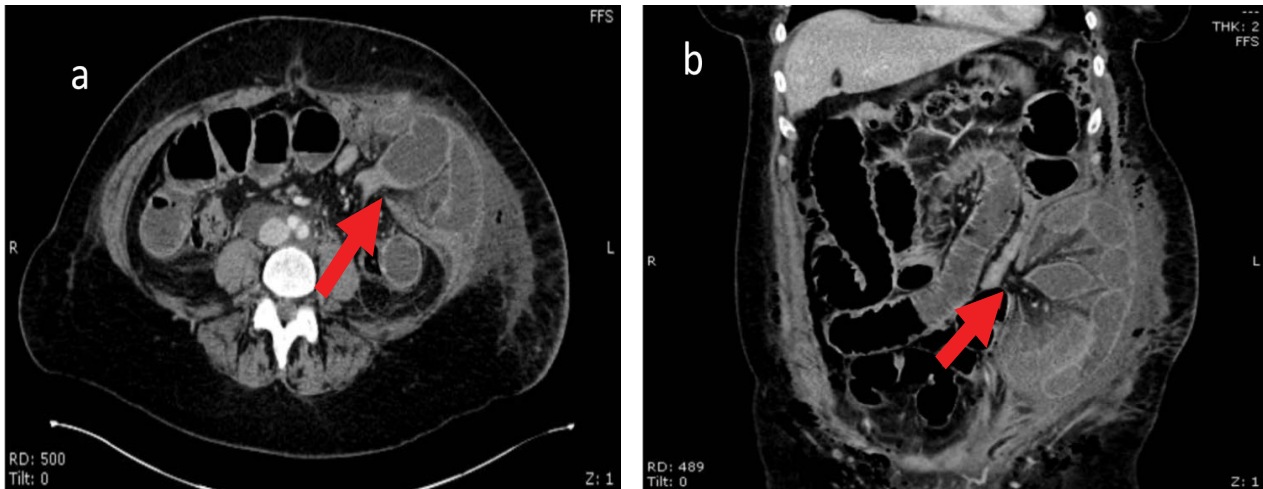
CT scan performed on post-operative day three for clinical indications of bowel obstruction show left extraperitoneal internal hernia. a) Transverse CT scan depicting left extraperitoneal herniation of small bowel through peritoneal defect (red arrow) with significant surrounding soft tissue inflammation and b) Coronal abdominal CT visualized incarcerated and strangulated loops of small bowel in the left extraperitoneal space through peritoneal defect (red arrow). Dilated proximal bowel loops of jejunum identified by the presence of plicae circulares proximal to bowel herniation.
